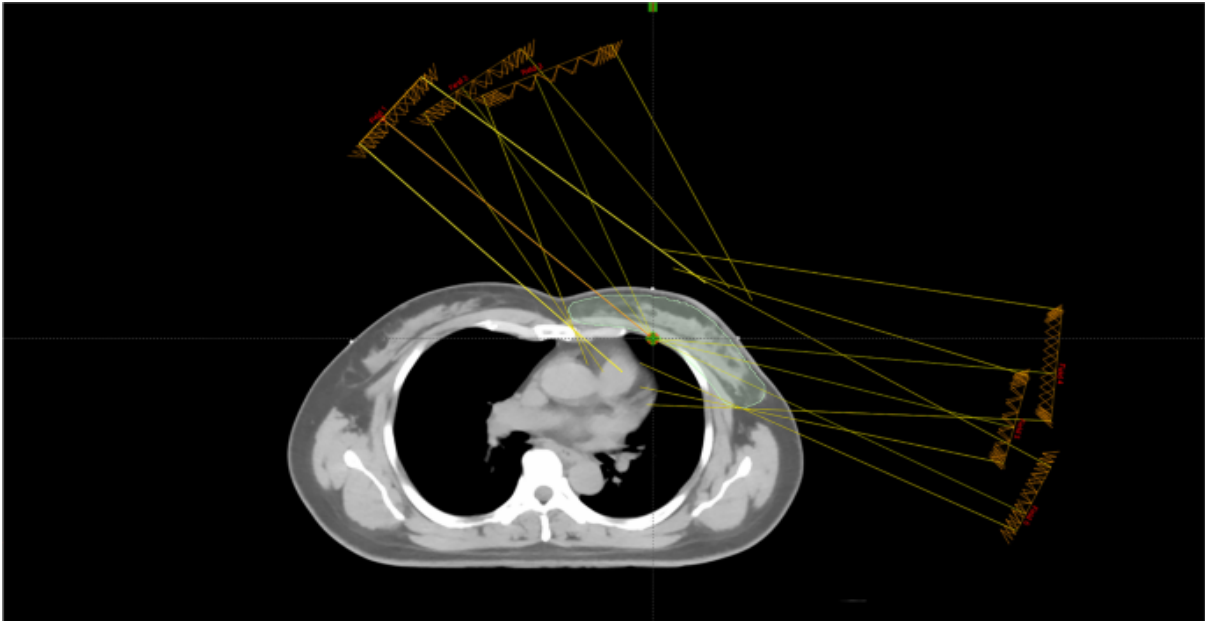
Transverse view of a CT image indicating the beam arrangement for intensity modulated radiation therapy.
